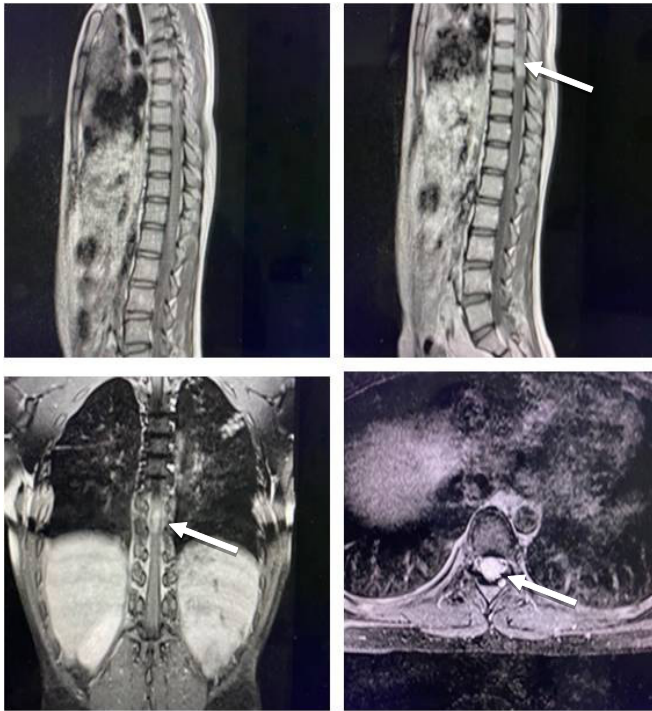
Spinal MRI (lesion marked by arrow).
